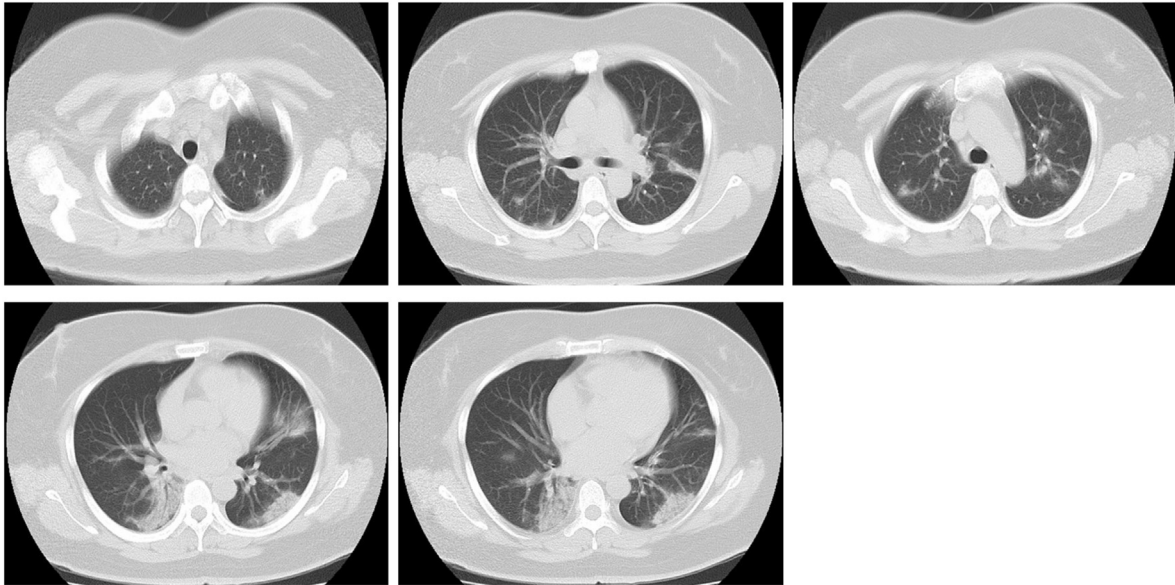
Chest CT on February 1.
